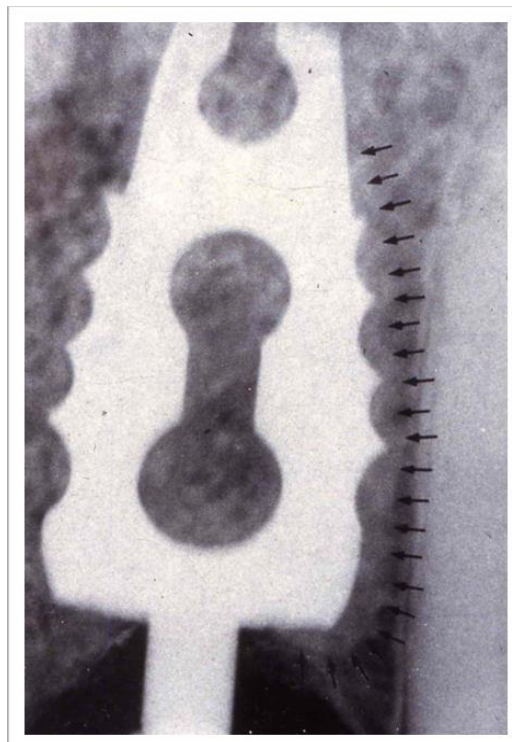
Appearance of the healed mucosa after 3 months around the protective Teflon abutment, The newly inserted definitive prosthetic abutment, The single gold-porcelain crown: observe the boy's beardless chin (1972) and the x-ray of the completed case.*
